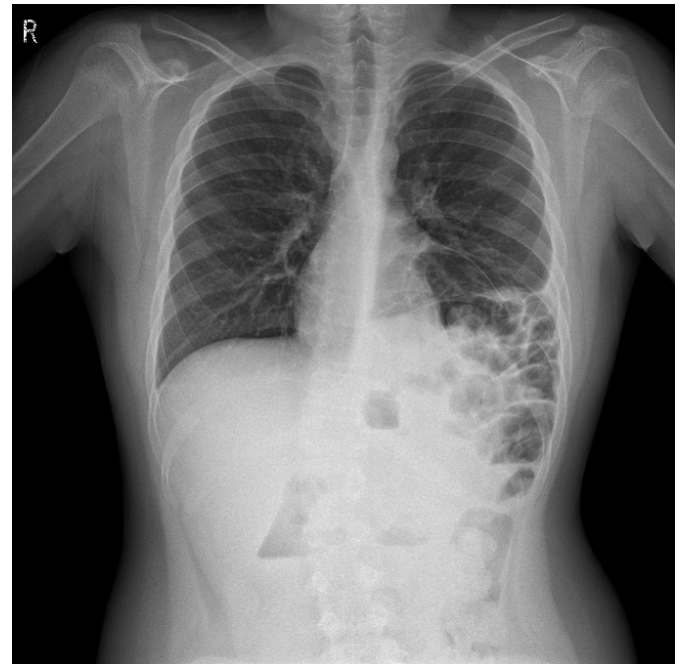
Initial chest X-ray showing elevation of the left hemidiaphragm and volume reduction of the left lung.
